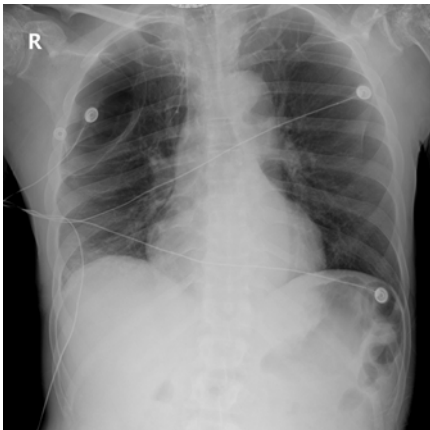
Chest X-Ray showing aortic atherosclerotic calcification and a large right-sided bulla. Red arrow indicates the large right-sided bulla. Taken and assessed on November 11, 2024.
